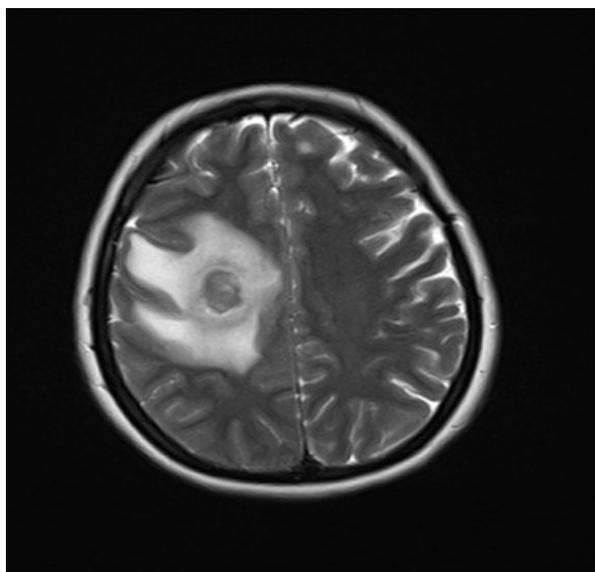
Brain MRI without contrast, showing right parietal lobe lesion.
